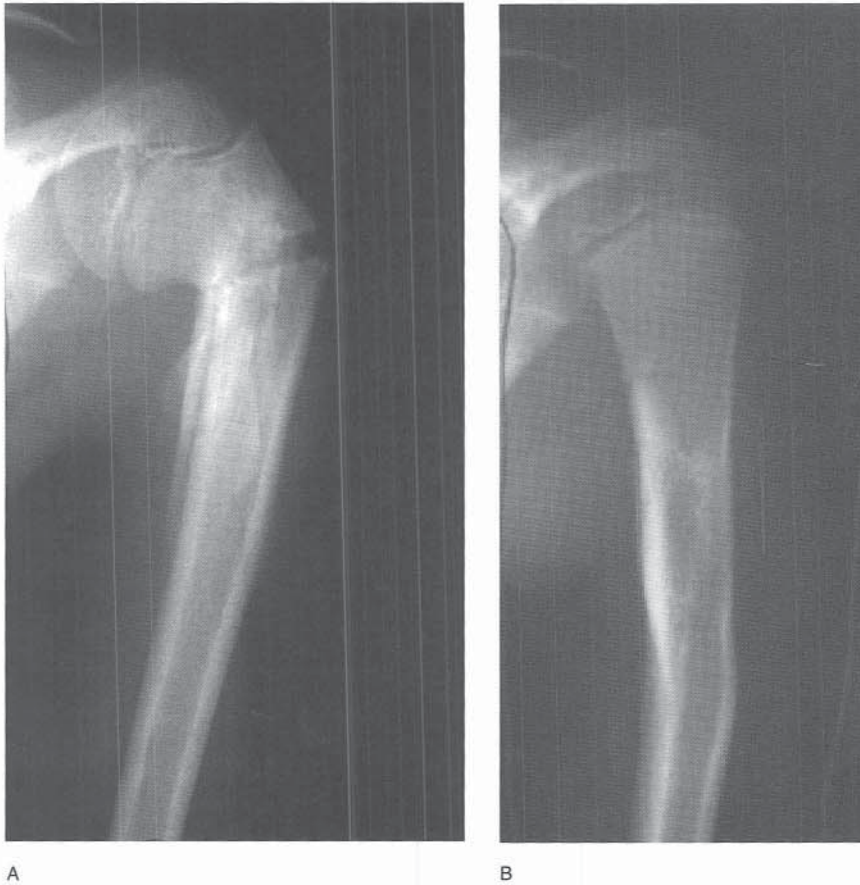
A, AP radiograph of a proximal humerus fracture in an 8-year-old boy. The fracture has healed with significant angulation. B, AP radiograph obtained 1½ years after injury demonstrates extensive remodeling of the proximal humerus.
